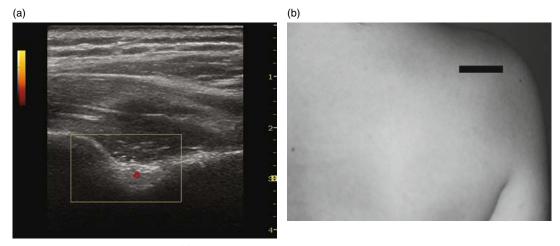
Spinoglenoid notch: (a) transverse ultrasound image of the spinoglenoid notch with color Doppler demonstrating the suprascapular artery and (b) the corresponding transducer position.
